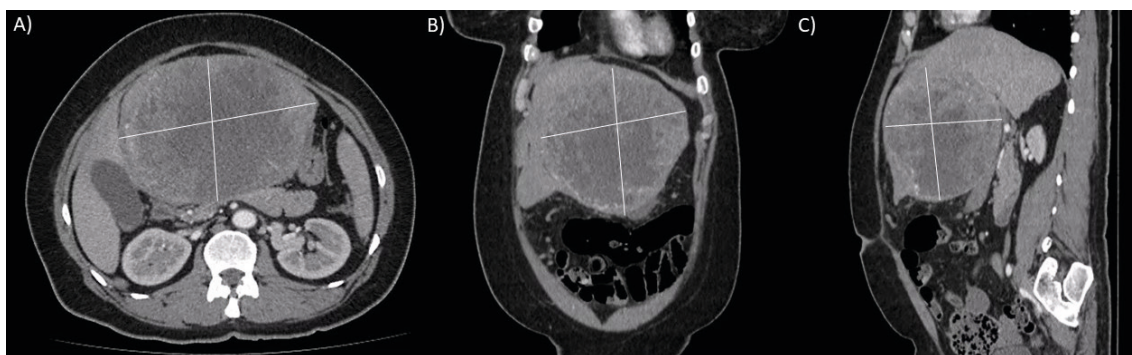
A) Contrasted CT in axial demonstrating a bulky solid expansive formation with heterogeneous contrast enhancement, presenting hypervascular foci with delayed washout and areas of cystic/necrotic degeneration in between, measuring approximately 15.3 x 13.7 cm (height x width) and occupying almost the entire left hepatic lobe. B) Coronal view of the mass. C) Sagittal view of the mass showing the depth measuring 11.1cm
